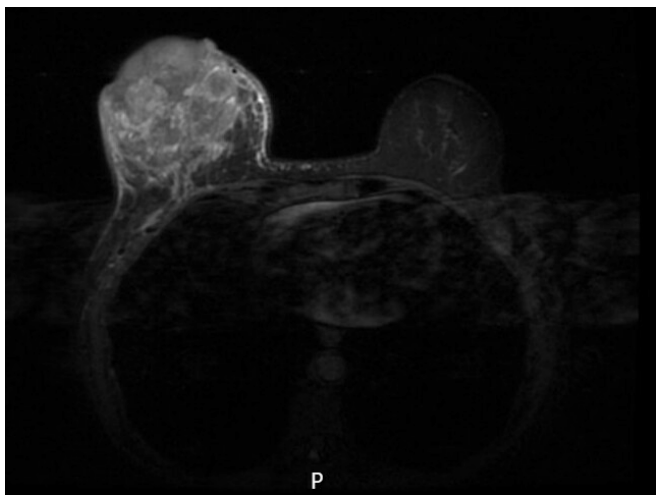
Staging Breast MRI (Axial T2 STIR sequence) 05/20/2025. 7.4×8.3×9.3 cm mass occupying most of the right breast, with an exophytic necrotic component, marked skin thickening, and edema tracking to the pectoralis fascia.
